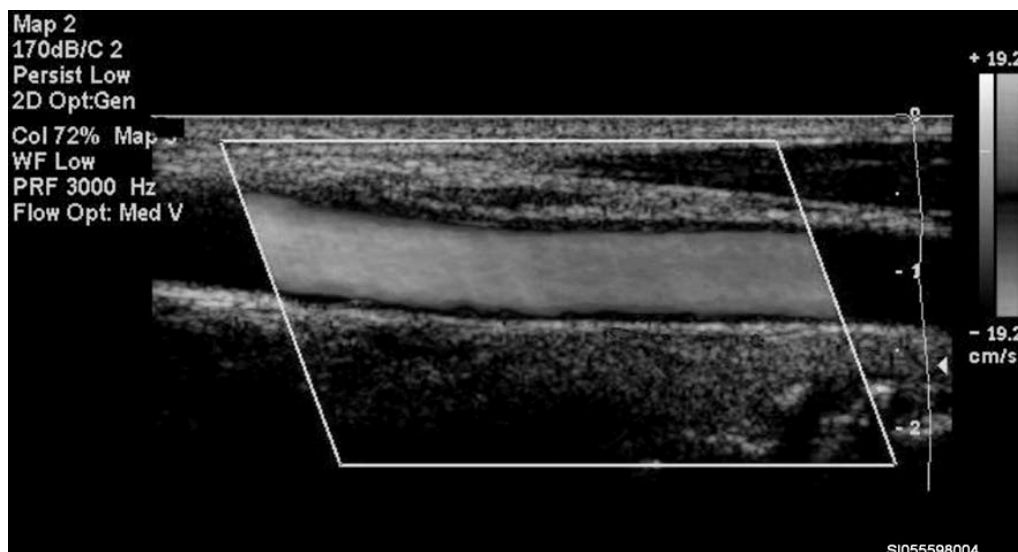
Doppler color image.
